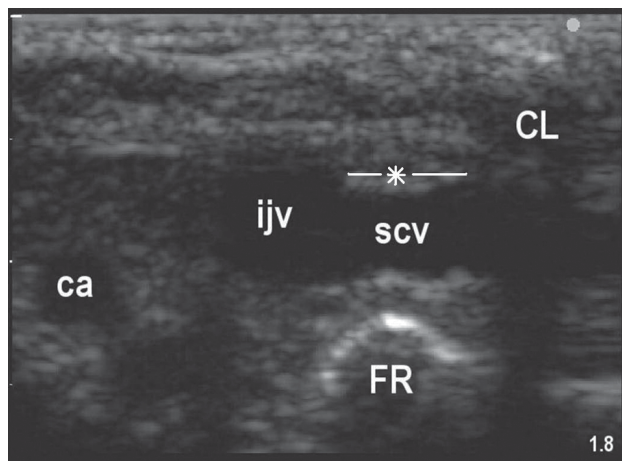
Ultrasonographic image obtained at the supraclavicular level in a 2.9 kg neonate. *Length of SCV visualized, this distance can be increased by pulling the arm downwards slightly. CL, clavicle; FR, first rib; SCV, subclavian vein; IJV, internal jugular vein; CA, carotid artery.
